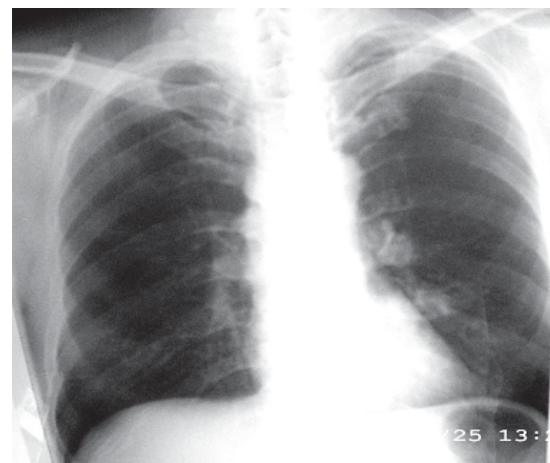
Left chest X-ray in the projection of the lower pole of hilar region showing an oval-shaped shaded area of 3 cm × 4 cm.
